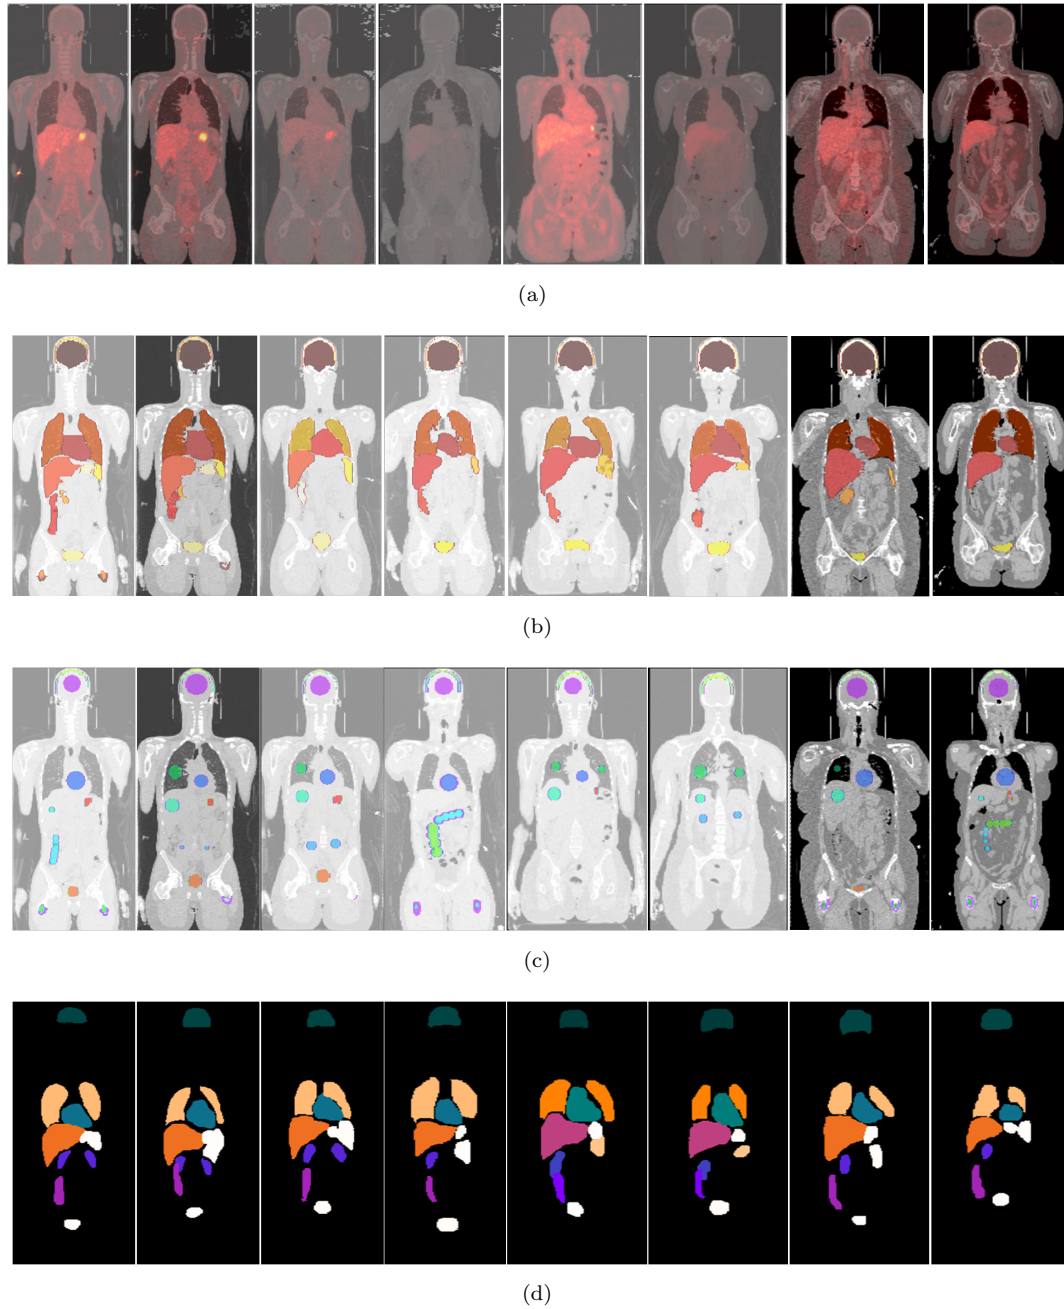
Coronal view of eight healthy human subjects: (a) CT images overlaid with whole-body PET images, (b) whole-organ ROI, (c) subsamples of the organs and (d) ROI delineated on antero-posterior projections, applied by one of the operators.
